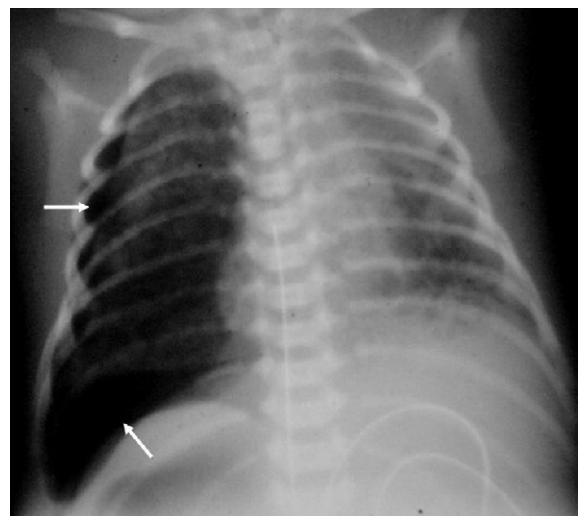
A chest radiograph of a premature infant with right tension pneumothorax (arrows) and partial collapse of right lung. The mediastinum is shifted to the left side.
